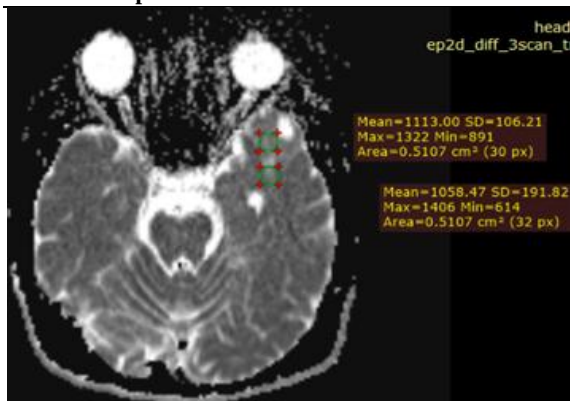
In the DWI sequence the lesion showed no diffusion restriction.
